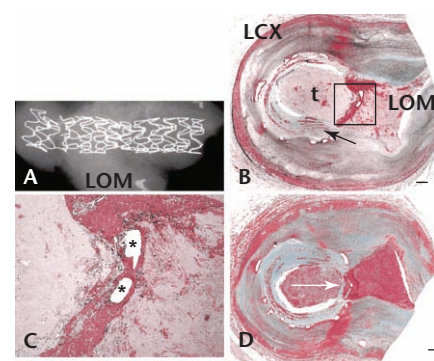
Postmortem radiography (A) shows a MULTI-LINK[®] stent crossing the ostium of the LOM branch. An occlusive, platelet-rich thrombus (indicated by t) at the ostium of the LOM is shown in a low-power view (B) and a high-power view (C; box in B). Stent struts across the ostium (C, indicated by *) are not covered by neointima. Struts in contact with the LCX plaque are covered with alternating layers of neointima and fibrin (B, indicated by black arrow). A deeper section (D) demonstrates in-stent restenosis, a neointima with layered fibrin overlying the LOM ostium (indicated by white arrow), and an occlusive luminal thrombus. (B, C, and D images are shown in Movat pentachrome; scale bars are 0.36 mm in B and D, and 0.18 mm in C). LOM, left obtuse marginal; LCX, left circumflex artery. Reprinted with permission from Farb A et al.² www.medreviews.com
